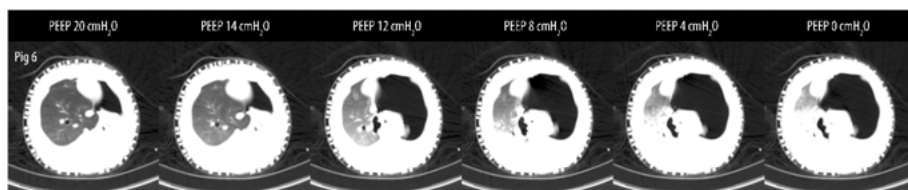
Representative CT images of the lungs during the decremental PEEP trial with images from PEEP 20 cm H₂O to the left to ZEEP at the right side of the figure. Aerated lung tissue decreased and atelectasis increased when the PEEP was lowered below 10 cm H₂O. Note the leftward mediastinal shift at PEEP levels of 20 and 14 cm H₂O making the surgical space smaller. CT = computerized tomography; PEEP = positive end-expiratory pressure; ZEEP = zero end-expiratory pressure.
